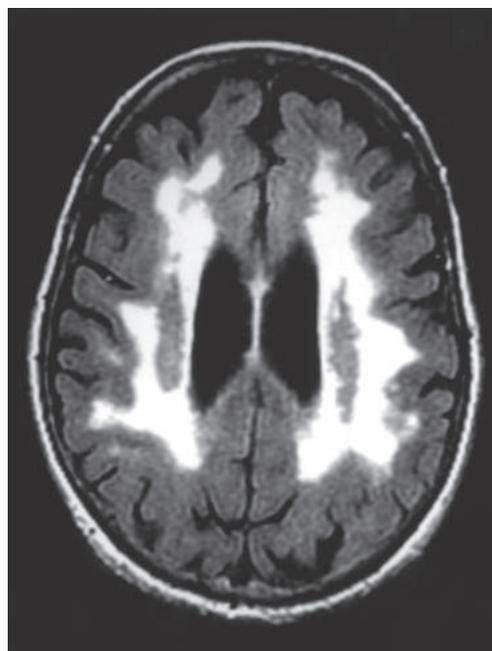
MRI Fluid Attenuation Inversion Recovery (FLAIR) image showing extensive white matter disease with confluent areas of leukoairiosis.
